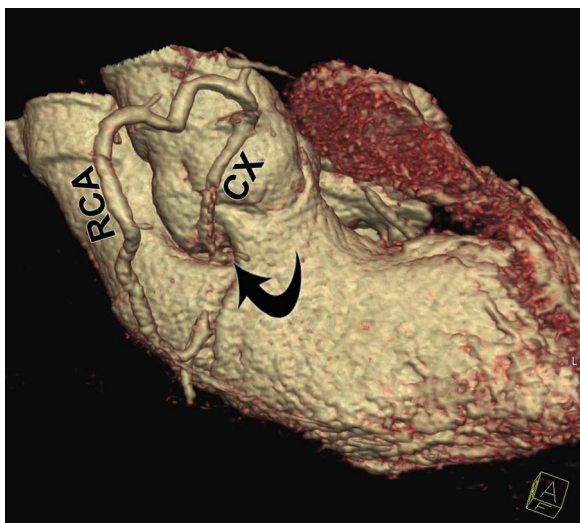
Right oblique three-dimensional volume-rendered CT image demonstrates the anomalous origin of the left circumflex artery (CX) from the right coronary artery (RCA) and its course in the groove between left ventricular outflow tract and anterior wall of the left atrium (arrow).
